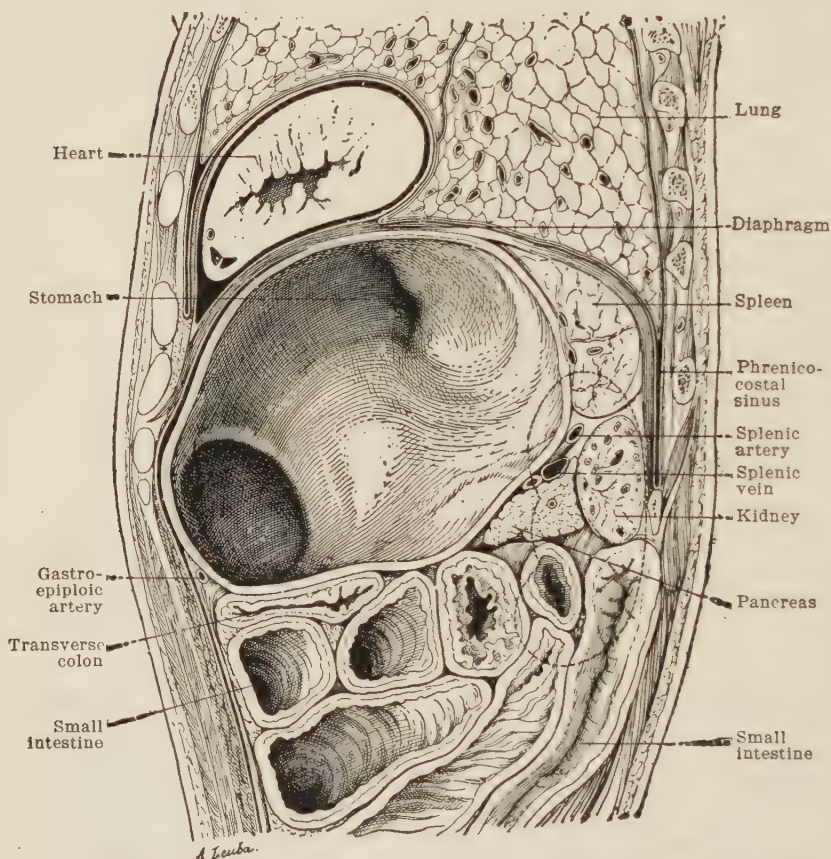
Sagittal section through the left hypochondrium, passing in the middle of the space between the parasternal and nipple lines, in a subject with marked dilatation of the stomach (*Luschka*).
